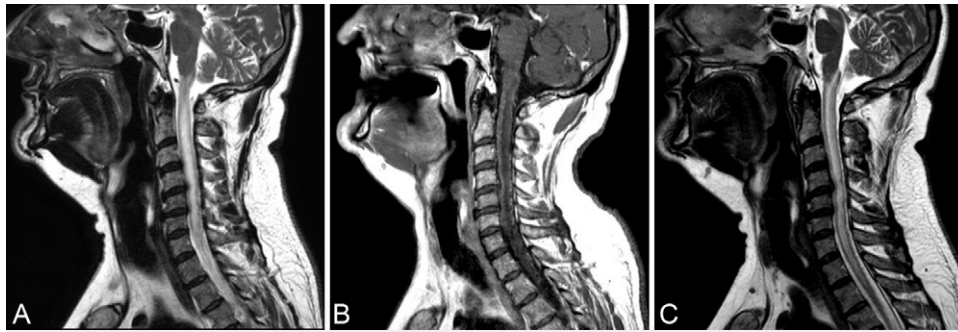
A: T2-weighted MRI sequence showing edema and spinal cord thickening from the craniocervical level down to C6, with no signal voids appreciated. B: Mild peripheral enhancement was demonstrated after gadolinium administration. C: Increased spinal cord edema up to the T2 level after 8 months.
